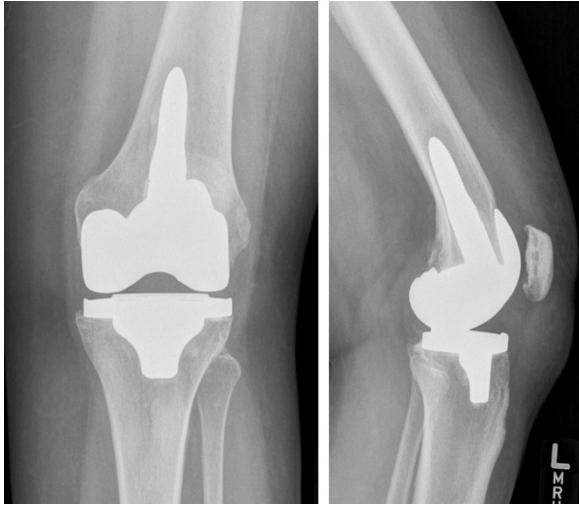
Six-week post-operative anteroposterior and lateral radiographs.
